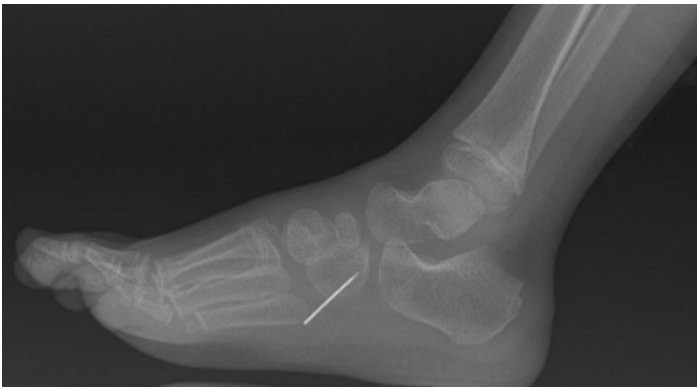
Direct radiography of the patient with a needle detected in his right foot.
